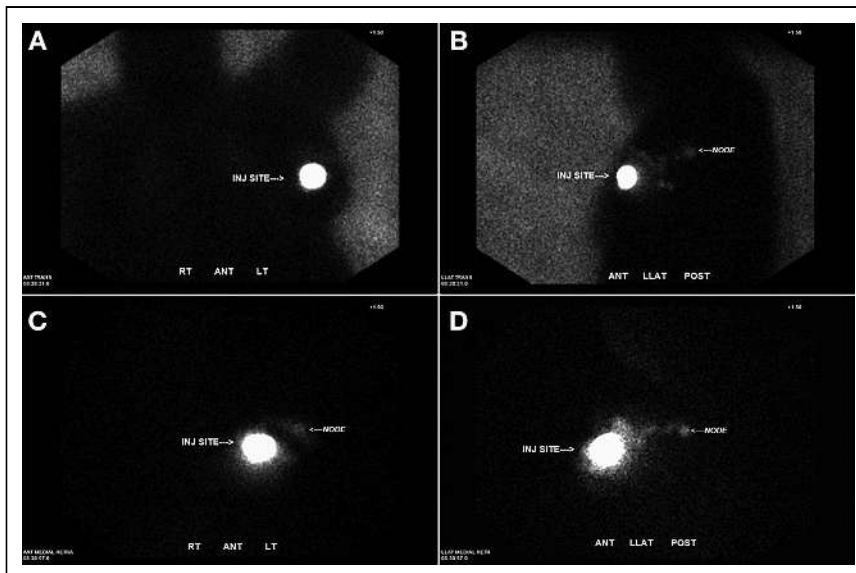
(A and B) Anterior (A) and lateral (B) ^{99m}Tc -tilmanocept lymphoscintigraphy images demonstrate focal areas of increased uptake superior and posterior to injection site, which likely represent lymph channels and axillary sentinel node. (C and D) Repeat anterior (C) and lateral (D) images during medial breast traction demonstrate marked improvement of visualization of lymph channels and sentinel node on anterior and lateral views.
